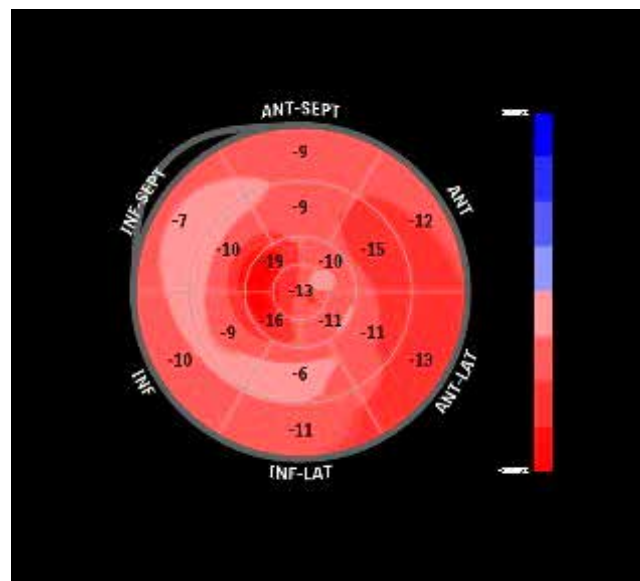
Speckle tracking echocardiography. Reduced left ventricular global longitudinal strain (GLS -11%). Severely impaired longitudinal function of the inferior and posterolateral wall
